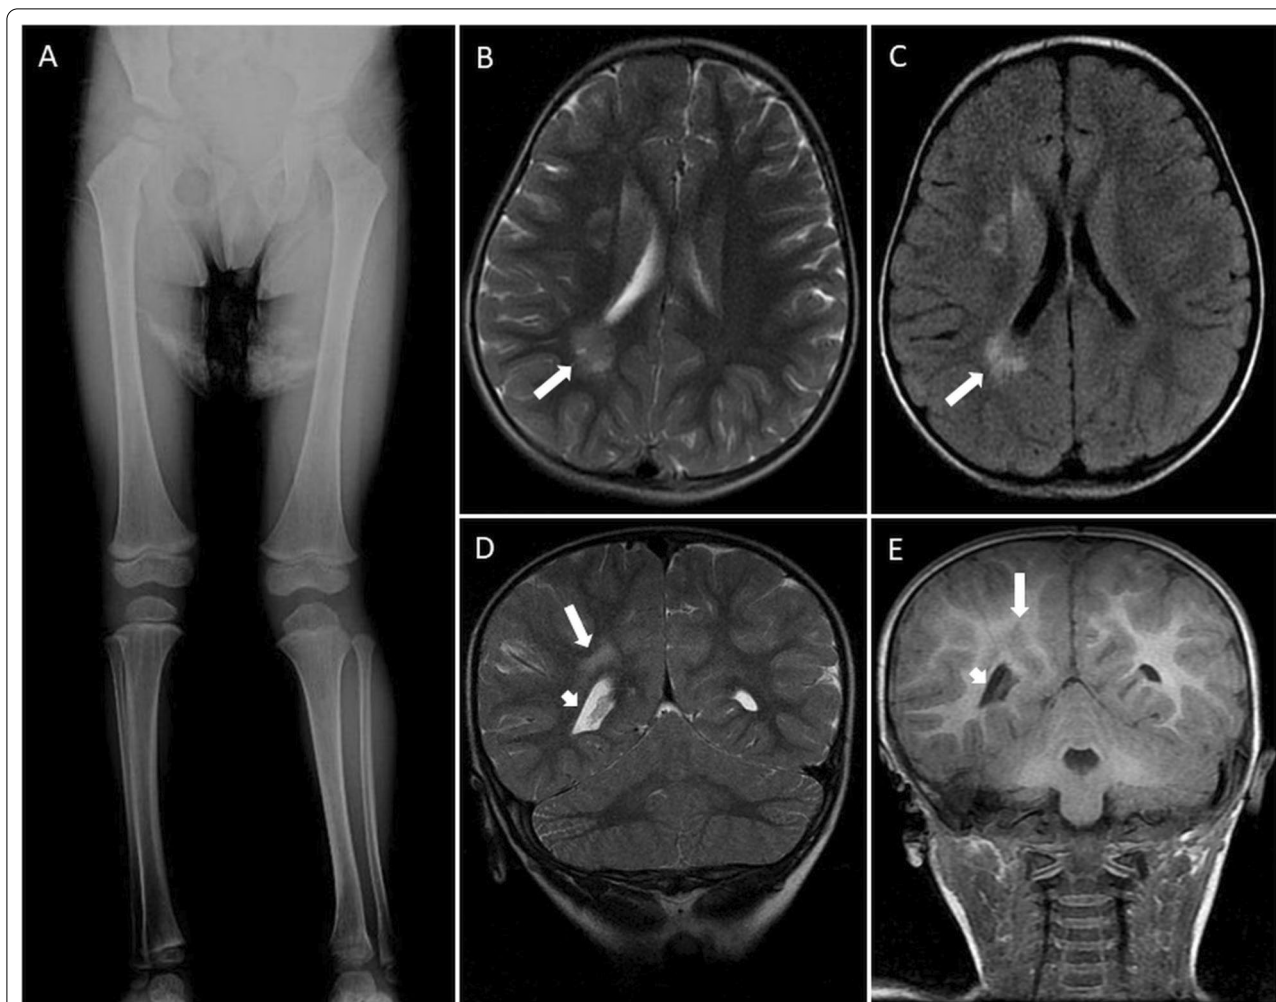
MR images of a 2-year-old female mild hemimegalencephaly in the right cerebral hemisphere with hypomelanosis of Ito. (a) Direct X-ray of the lower extremity shows hemihypertrophy in the left lower extremity. (b) axial T2-weighted; (c) axial FLAIR; (d) coronal T2-weighted series show amorphous, hyperintense white matter lesions extending from the basal ganglia to the ventricular body and the periventricular fronto-parieto-occipital white matter (thick arrows). (e) Coronal 3D spoiled gradient-recalled (SPGR) T1-weighted series shows isointense lesions (thick arrows) with grey matter in periventricular white matter areas in the right basal ganglia-corona radiata plane and dilatation of the lateral ventricle (arrowheads)
